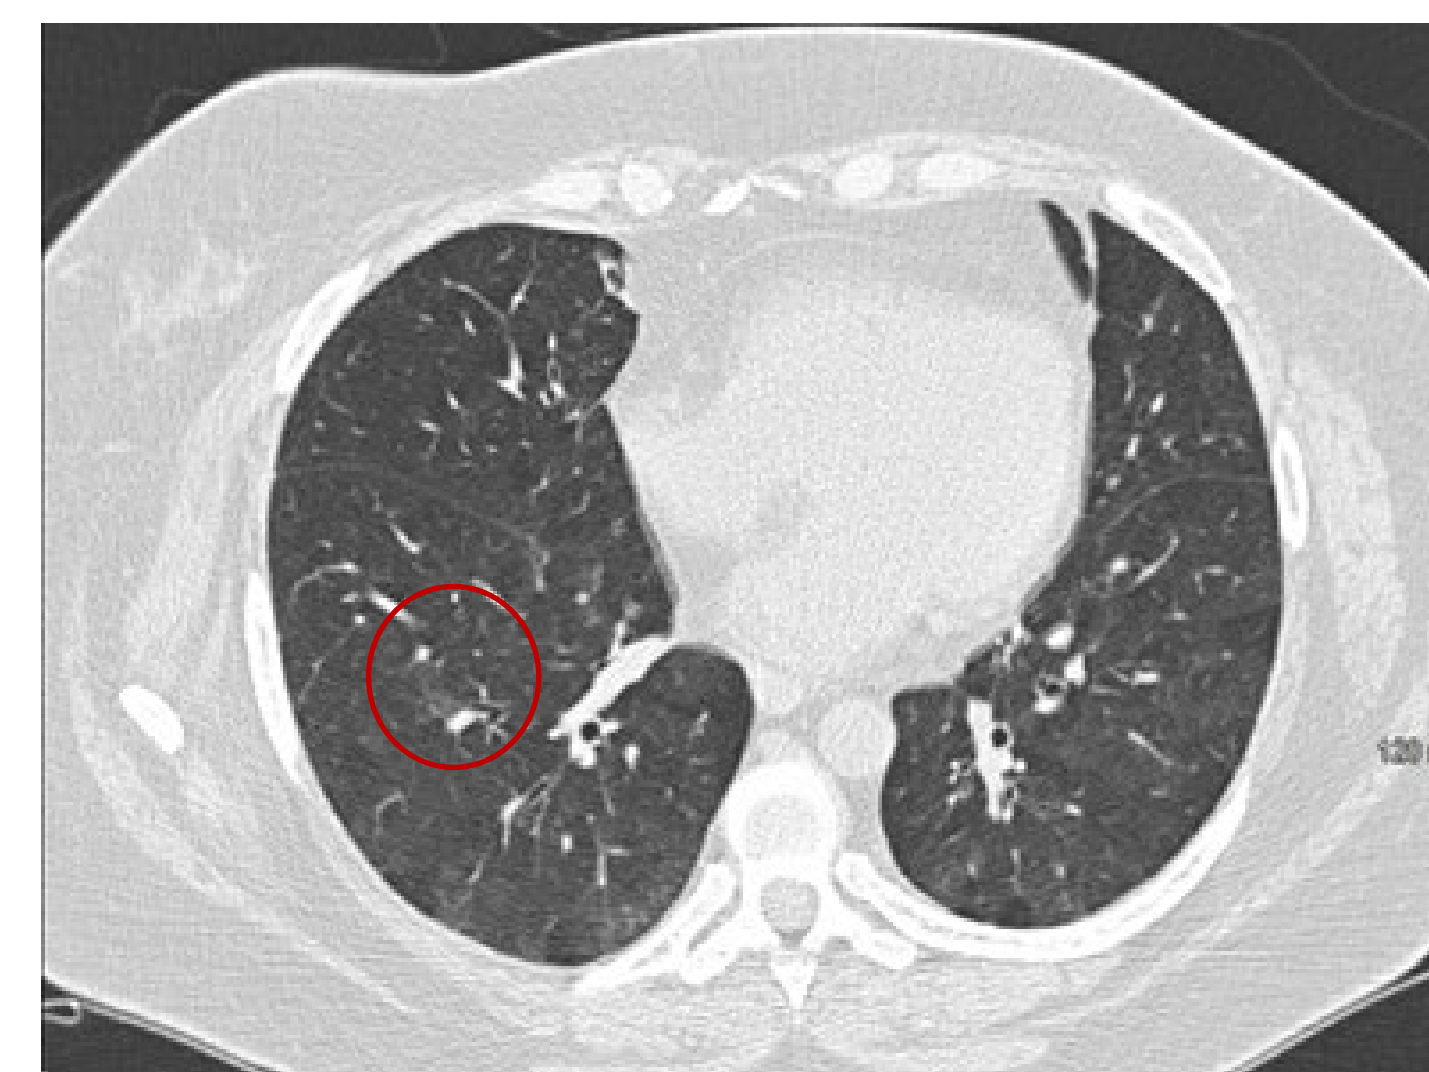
CT scan of the chest, coronal view, showing mosaic pattern ground glass opacities
